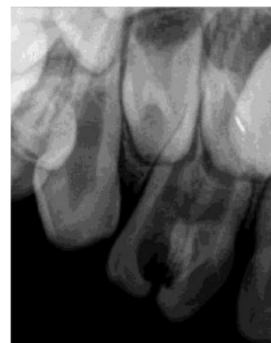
Preoperative radiograph showing fusion of supernumerary tooth with maxillary right lateral incisor.
